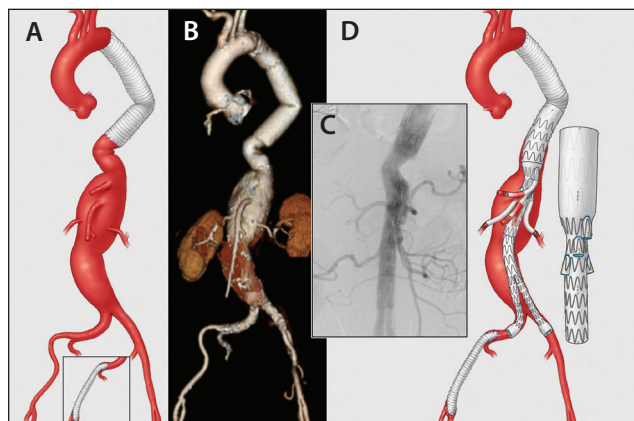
A patient who was treated with the multibranched stent graft. The aneurysm distal to thoracic aortic graft (A) and preoperative CT angiography of a large TAAA (B). Completion angiography showed no endoleaks (C), and the repair was completed using a four-vessel multibranched stent graft (D).
